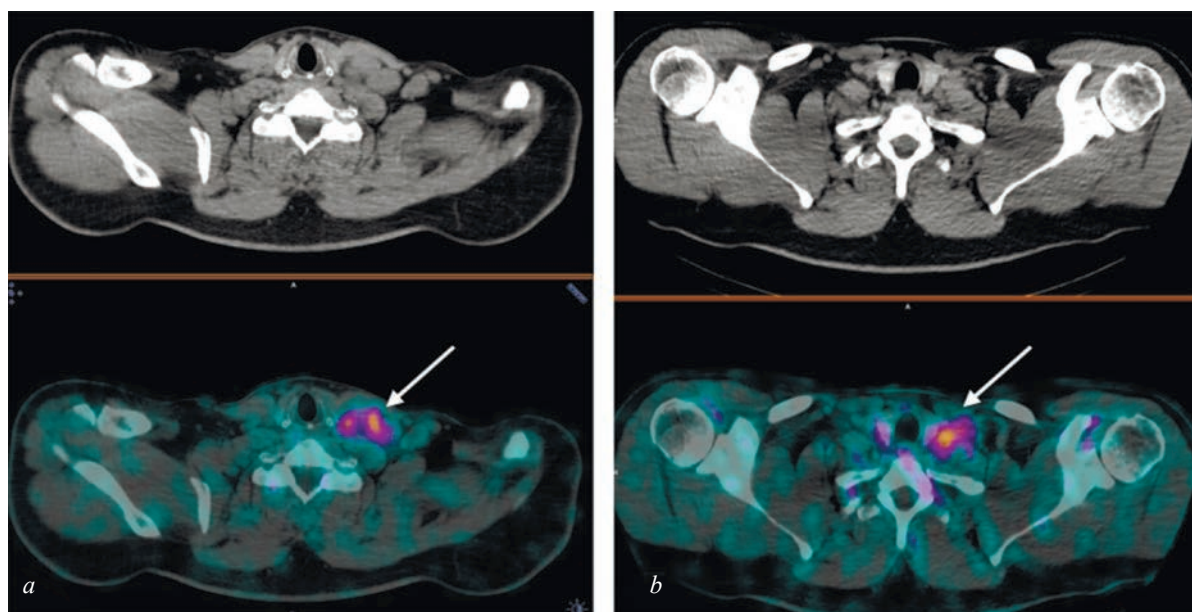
CT and combined SPECT/CT images at 2 h after administration of [$^{99\text{m}}\text{Tc}$]Tc-HYNIC-PSMA in a patient with Hodgkin's lymphoma, with damage to the cervical and supraclavicular lymph nodes, the arrow indicates the tumor: *a* – before therapy, SUVmax 4.03; *b* – after 4 courses of polychemotherapy according to the BEACOPP protocol, SUVmax 1.46 (self-reported)
